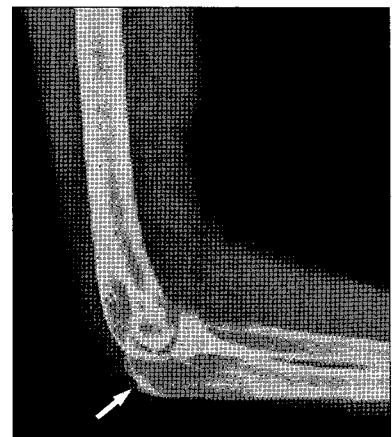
Preoperative simple radiograph of the right elbow shows osteophyte formation.
